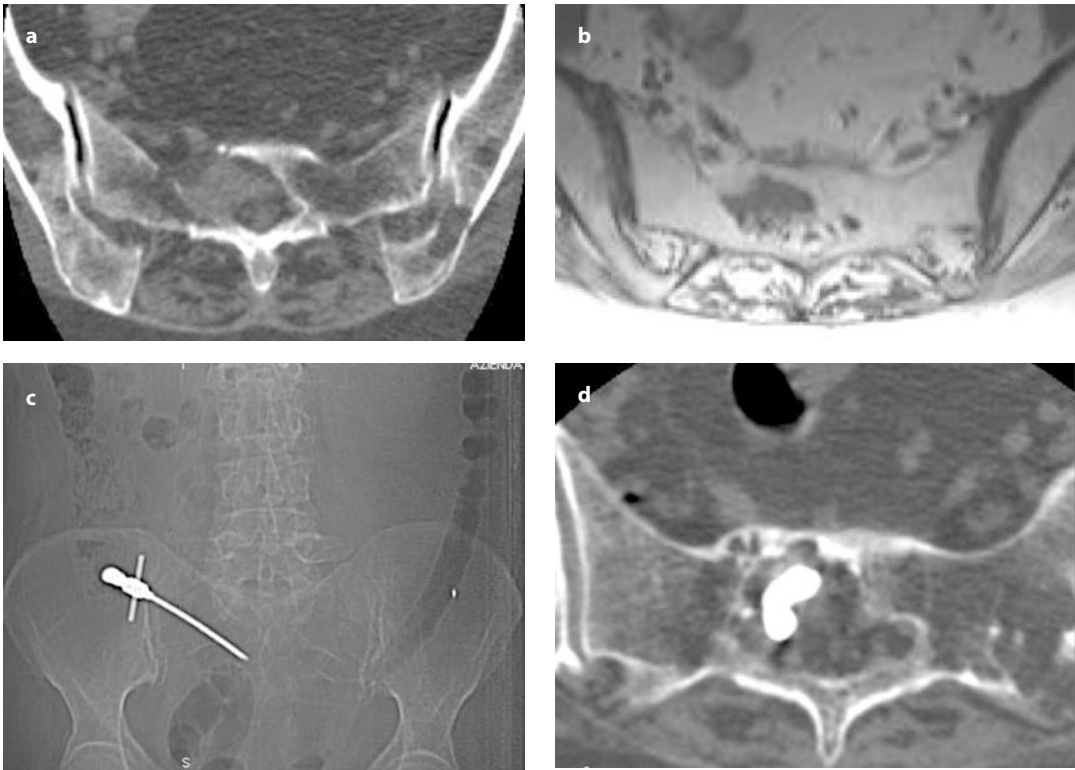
Small sacral lesion and targeted PMMA injection in a patient with multiple myeloma. On CT (a) and T1-weighted MRI (b), a small lesion can be observed at the body-to-wing line of the sacrum. A 11-G needle is placed carefully into the lesion *via* a CT-guided transalar approach (c) and the lesion filled with PMMA, resulting in pain resolution (d)
